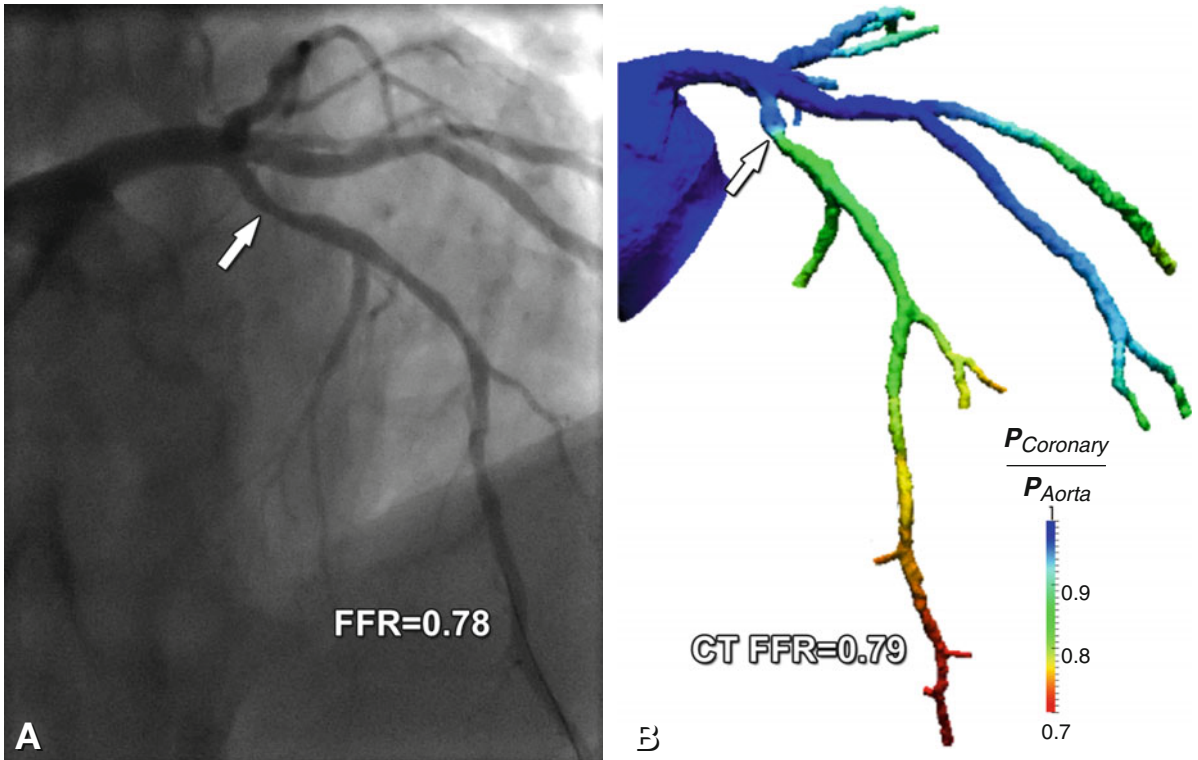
A patient with chest pain and a 60% angiographic stenosis in the proximal left anterior descending artery (*arrow in Panel A*). Coronary CTA showed a >50% stenosis, and computed FFR in the left anterior descending artery was 0.79, indicating a functionally significant stenosis (*arrow in Panel B*). This was confirmed by an invasively measured FFR of 0.78. The patient underwent successful stenting of the LAD stenosis with relief of angina symptoms and good long-term outcome
